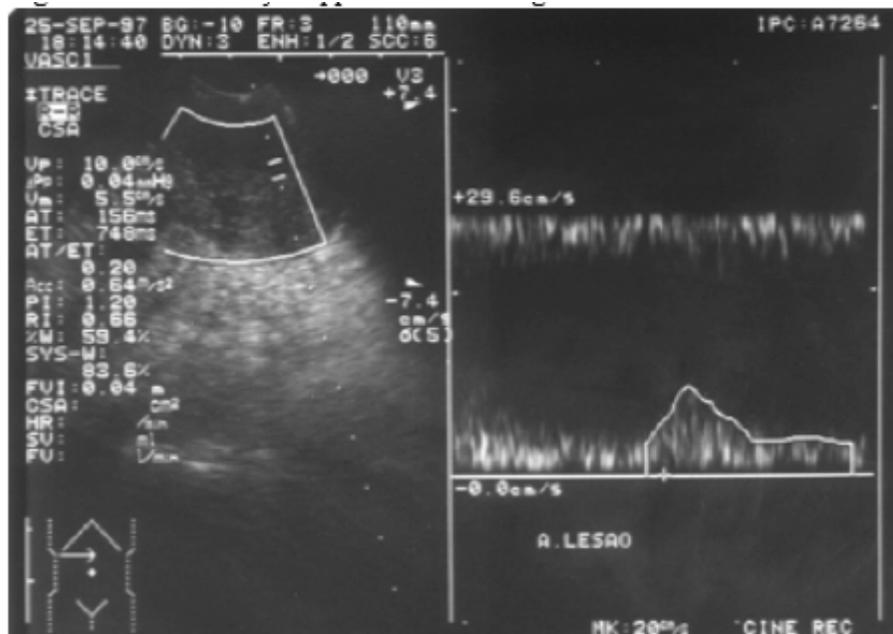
Tumor artery Doppler scan showing central and abundant flow.
